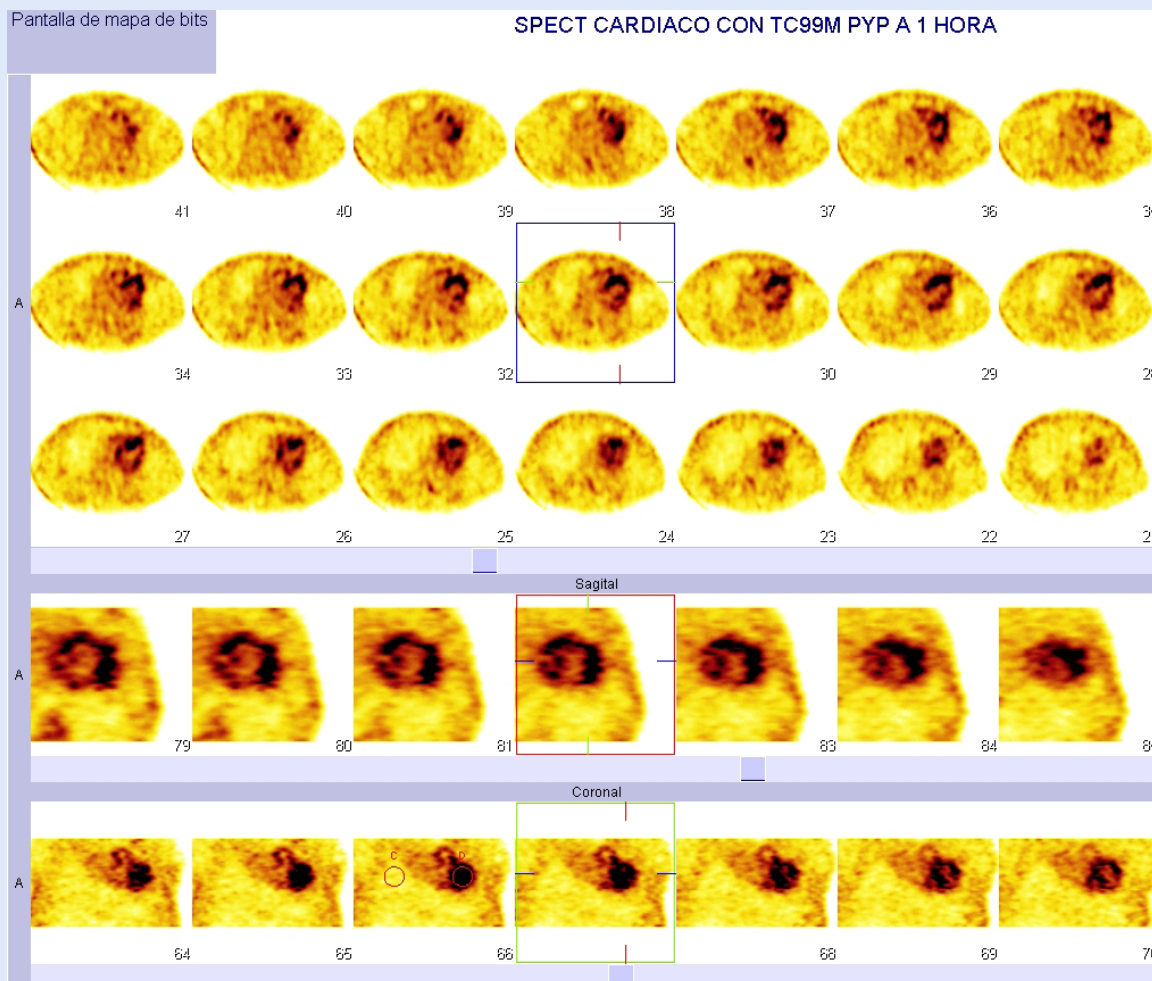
Case 1. Cardiac SPECT was acquired one hour after the injection of 20 mCi of ^{99m}Tc-PYP. Axial, sagittal, and coronal tomographic images demonstrate diffuse radiotracer uptake throughout the myocardium, confirming that the activity is not due to residual blood-pool signal.
